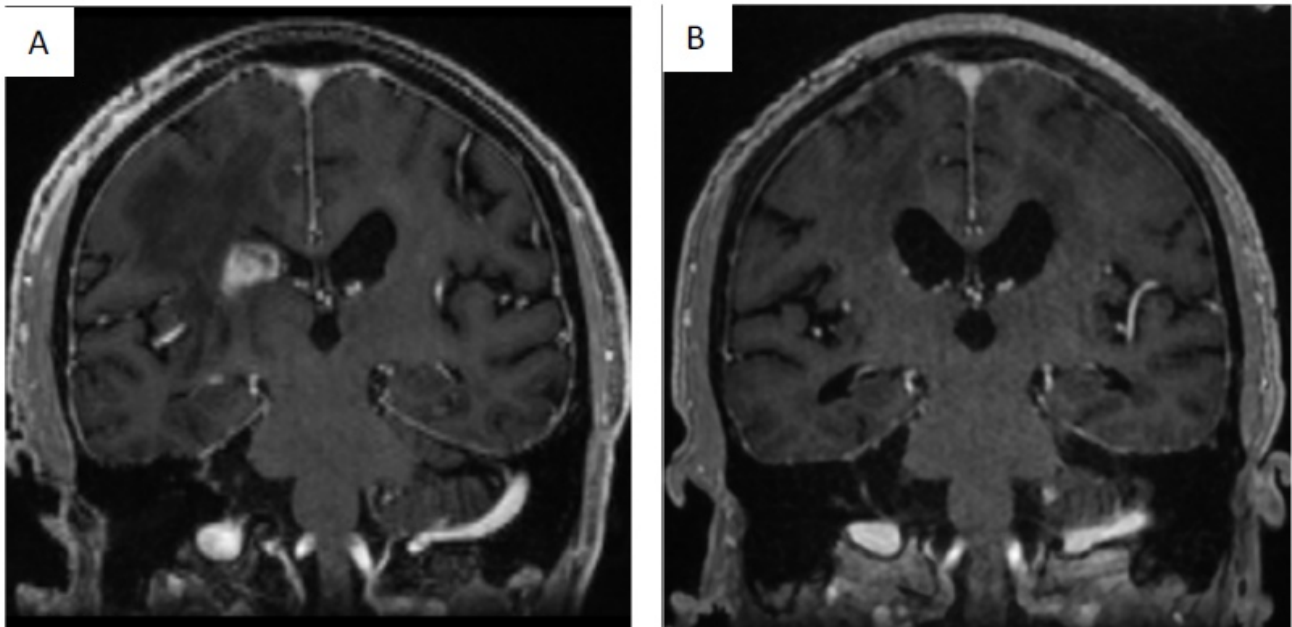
MRI Images of primary CNS ALK-negative anaplastic large cell lymphoma. A. Repeat MRI after steroid tapering shows multifocal contrast enhancing lesions involving the right periventricular region. B. Repeat MRI two month after radiation shows no evidence of residual/recurrent contrast enhancing lesions
